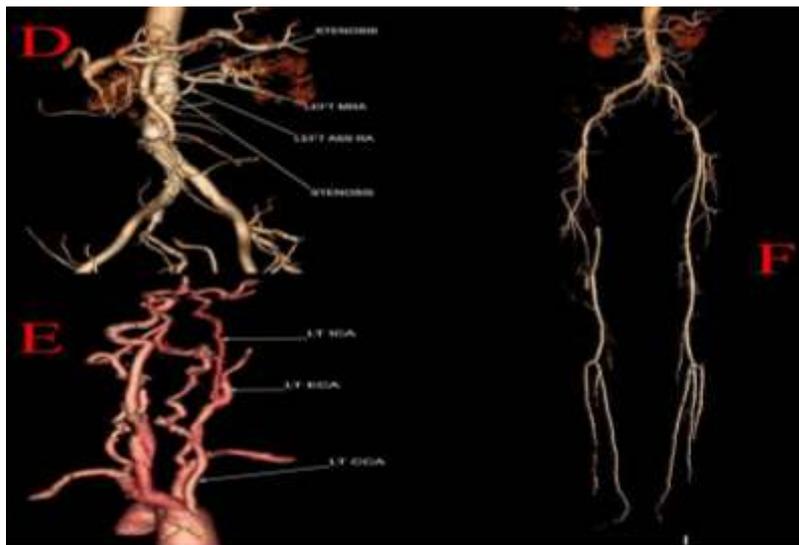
D) VR image of CT abdominal angiography showing ostial stenosis of left main and accessory renal artery. E) VR image of CT carotid angiography showing severe degree long segment stenosis of left internal carotid artery. F) VR image of CT lower limb angiography showing total occlusion of right proximal superficial femoral artery, mid and lower part of left anterior tibial artery and bilateral dorsalis pedis artery.
